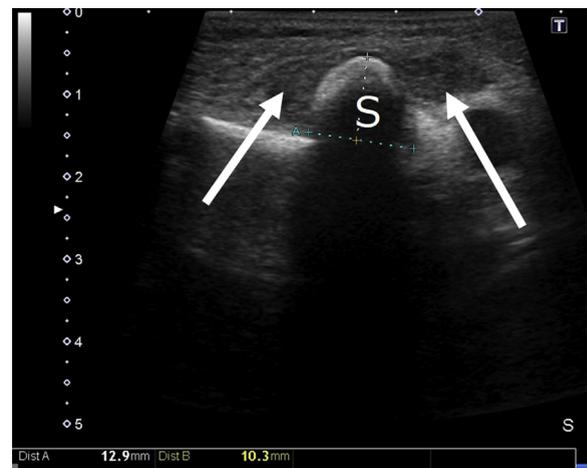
Midline sagittal sonogram of the sternum showing disruption in the surface of the sternum, with purulent material (indicating by arrow) around the area of fracture of the sternum (S).
